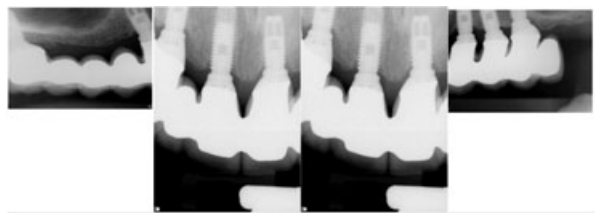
Anterior postoperative periapical radiographs of the patient in Figure 9, 1 year after completion of implant prosthodontic therapy. All teeth were extracted, and implants were placed to support a maxillary fixed implant prosthesis.
